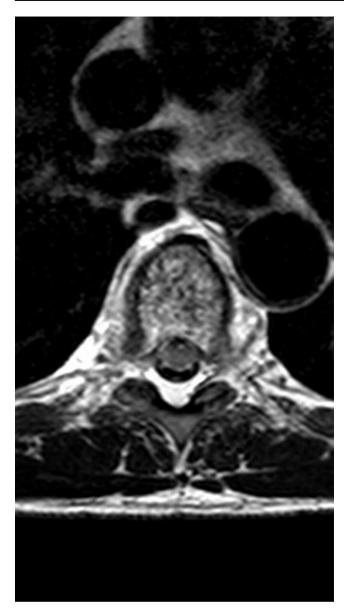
Transversal T2-weighted MRI of the thoracic spine.
